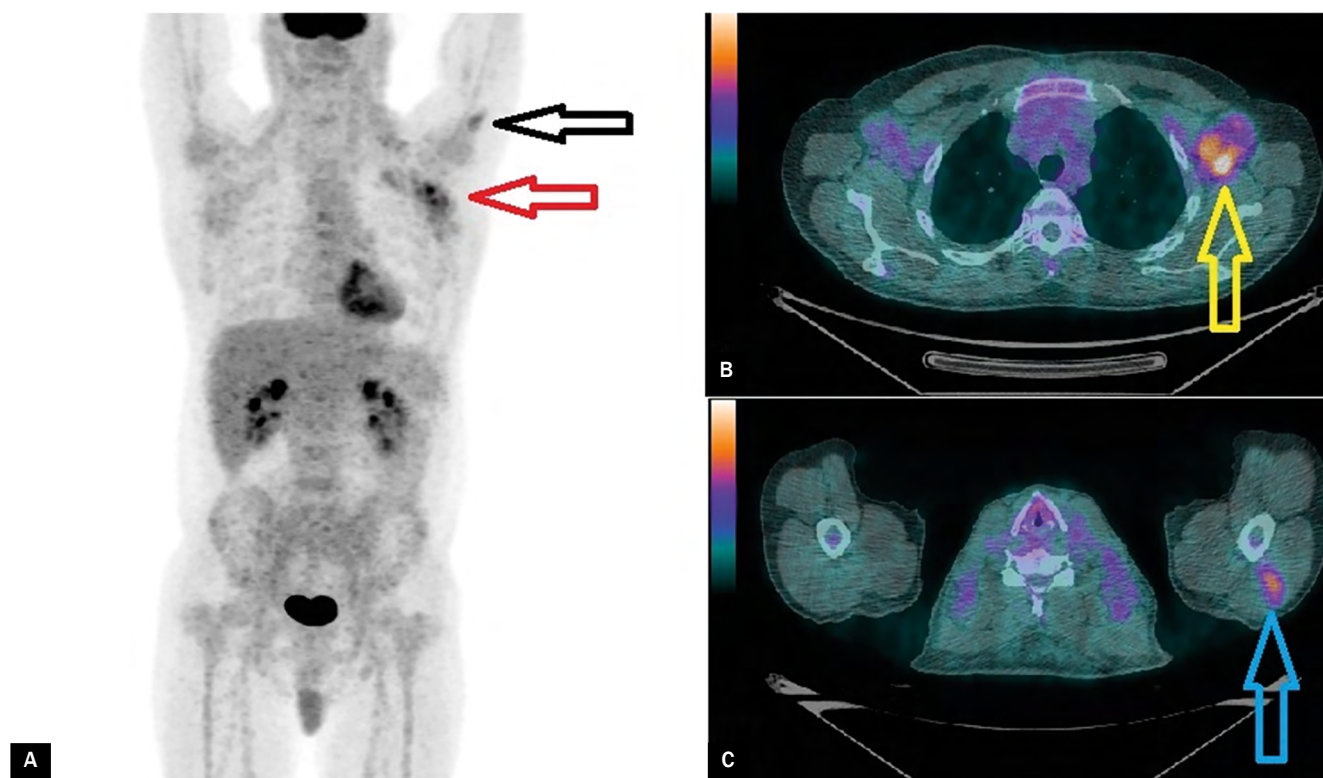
PET/CT images were performed 2 days after the second dose of the COVID-19 vaccine (A, B, C). The multiple-intensity projection image (A) shows moderately increased [¹⁸F]FDG uptake in the left triceps brachii muscle (black arrow), in the left axillary region (red arrow), and only slight uptake in the enlarged lymph nodes of the neck, right axilla, anterior mediastinum, and both inguinal regions. Fused axial image (B) presents the focal uptake in the axillary lymph node (yellow arrow) and (C) accumulation of the tracer in the left triceps brachii muscle (blue arrow)
